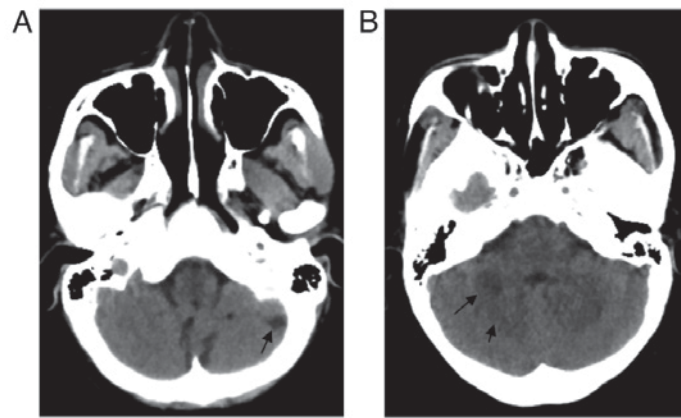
Computed tomography revealed multiple low-density lesions on each side of the cerebellar hemisphere and cerebellar vermis. (A) Low density lesion on the left cerebellar hemisphere. (B) Low density lesions on the right cerebellar hemisphere.
